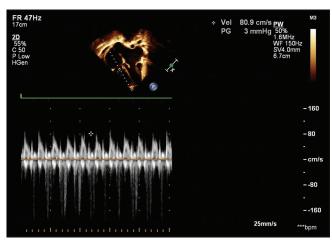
Lack of respiratory variation in tricuspid valve Doppler
